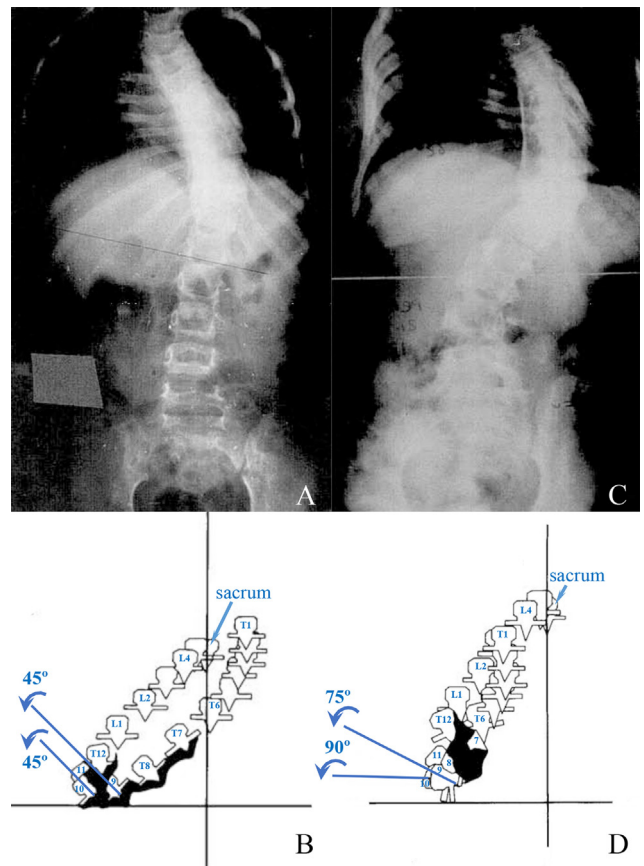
The crankshaft phenomenon [10]. Postero-anterior radiographs obtained before surgery (A) and some time after surgery (C) in the same patient. Top views before surgery (B) and some time after surgery (D): due to the major rotation ($> 90^\circ$) of the apical vertebra (T10), the fusion mass (in black) gradually moved forwards towards the vertebral bodies. Consequently, growth of the vertebral bodies caused not only additional angulation and rotation of the spine, but also apparent progressive kyphosis.
